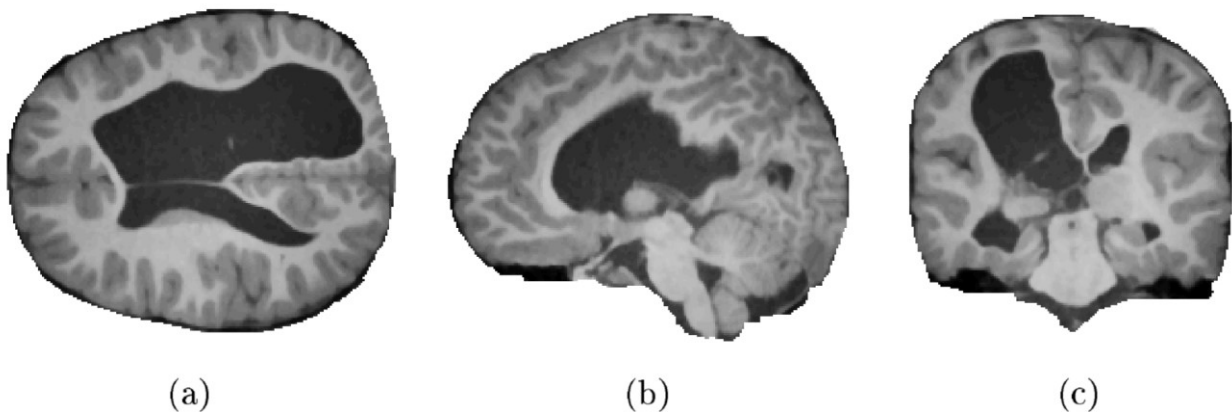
The computed brain mask obtained from an MR image of a 5 year old male, clinically diagnosed with CP, using the in-house developed brain masking algorithm. This MRI shows severe ventricular enlargement, particularly in the right hemisphere. (a) Axial, (b) sagittal and (c) coronal views are shown.
